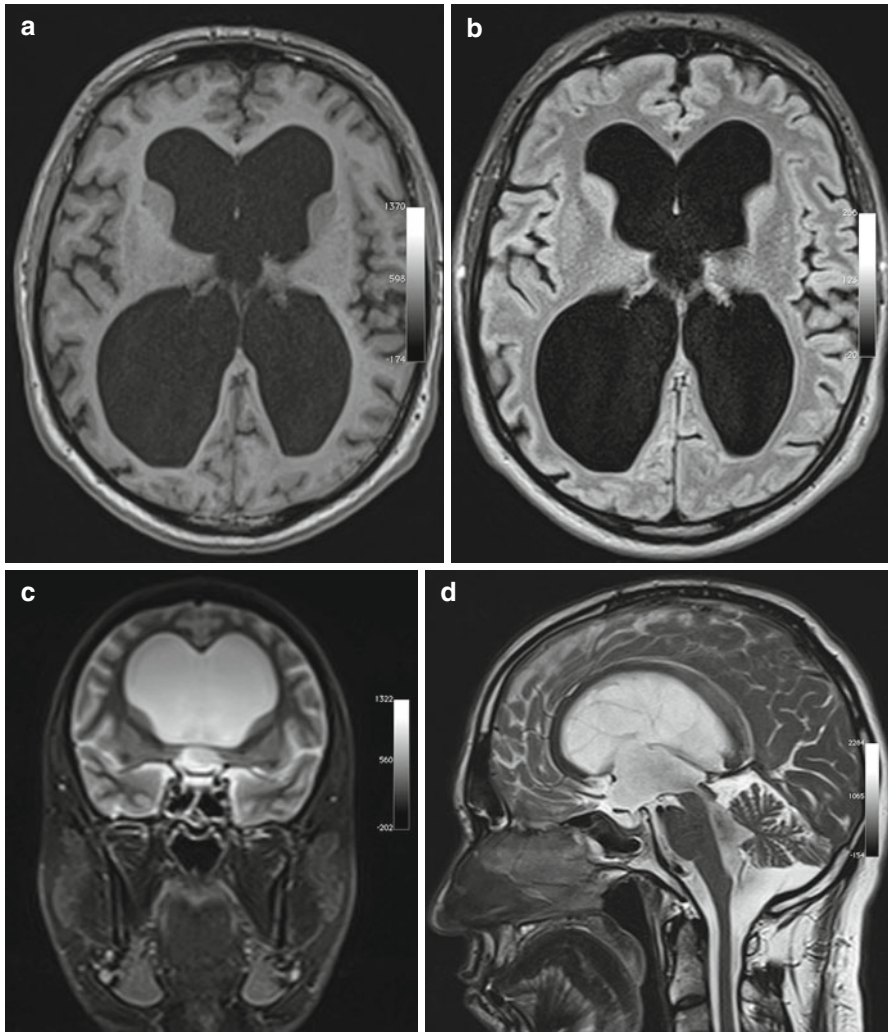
Incidental screening findings in a 74-year-old male subject with a history of loss of cognitive function and small-stepped gait having persisted for some time. In conjunction with the clinical presentation, the morphologic changes seen on MRI give rise to the suspicion of NPH. Axial T1w MPR image reveals symmetrically dilated internal CSF spaces (a) without any significant periventricular signal changes on axial T2w FLAIR image (b). Coronal T2w TIRM image shows very narrow external CSF spaces supratentorially (c). Sagittal T2w TSE image shows strong flow signal over the aqueduct (d)
